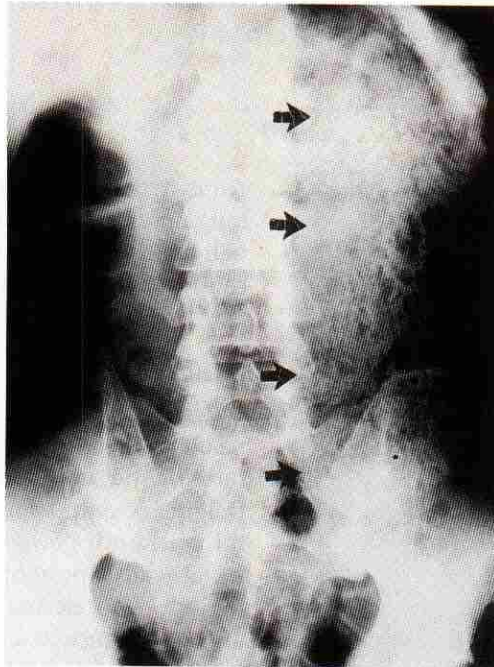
Plain supine abdominal radiograph of a 36-year-old woman with Hirschsprung's disease and chronic constipation. Retention of fecal material (fecaloma) in a dilated segment of the sigmoid and descending colon represents fecal impaction (arrows).
